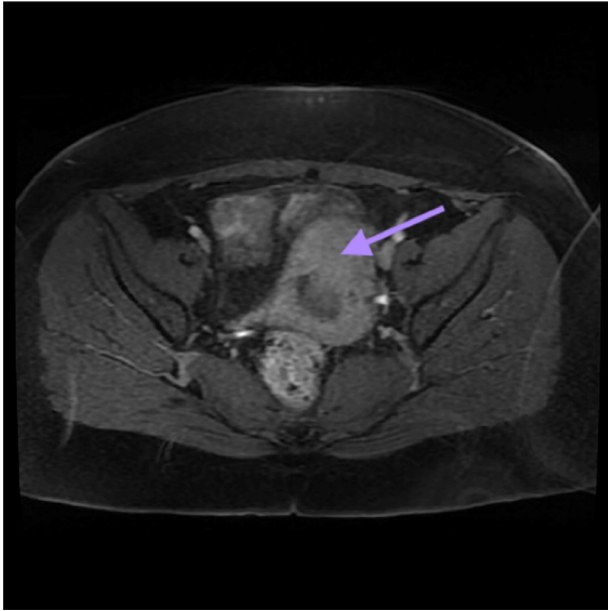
Axial T1 FS view of the tumor on MRI postgadolinium.
